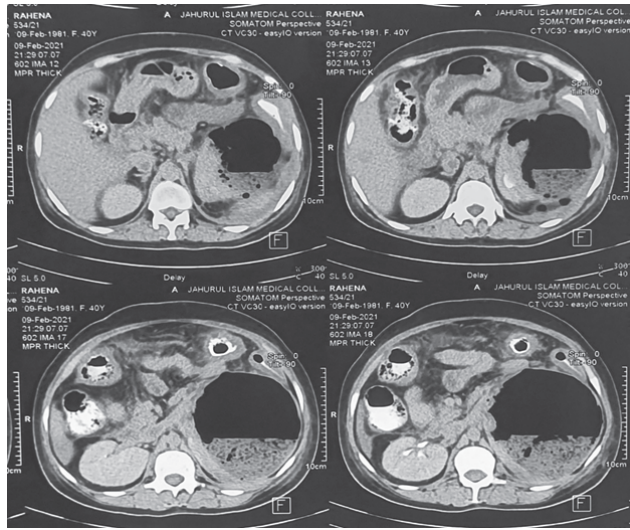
CT scan of abdomen with contrast showing hugely enlarged left kidney with multiple areas of air density with perinephric fat stranding consistent with left-sided emphysematous nephritis. (Axial plane).
